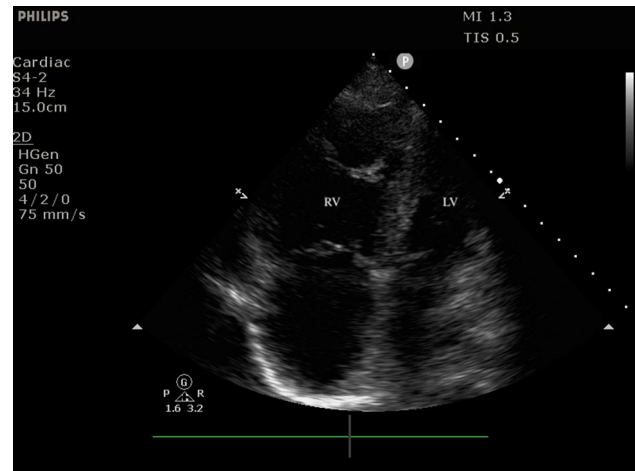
Transthoracic apical four-chamber view showing a severely dilated right ventricle (RV)
